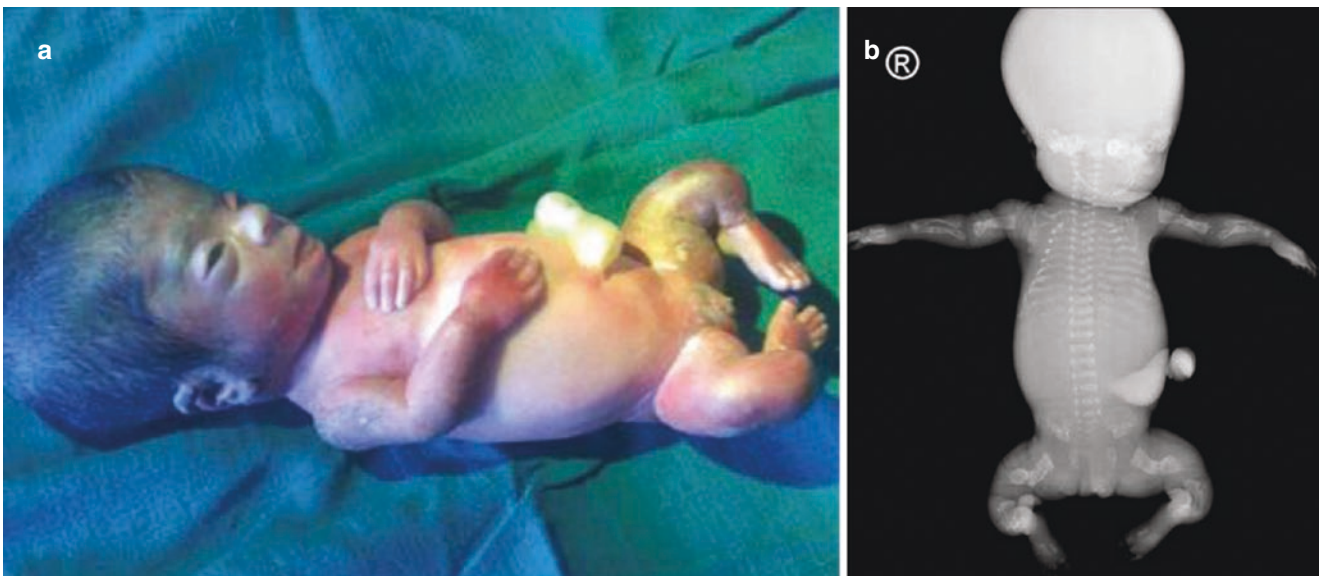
The same fetus as Fig. 2.109. Osteogenesis imperfecta is confirmed after induced labor. (a). Image of the fetus after induced labor. (b). X-ray of the same fetus
